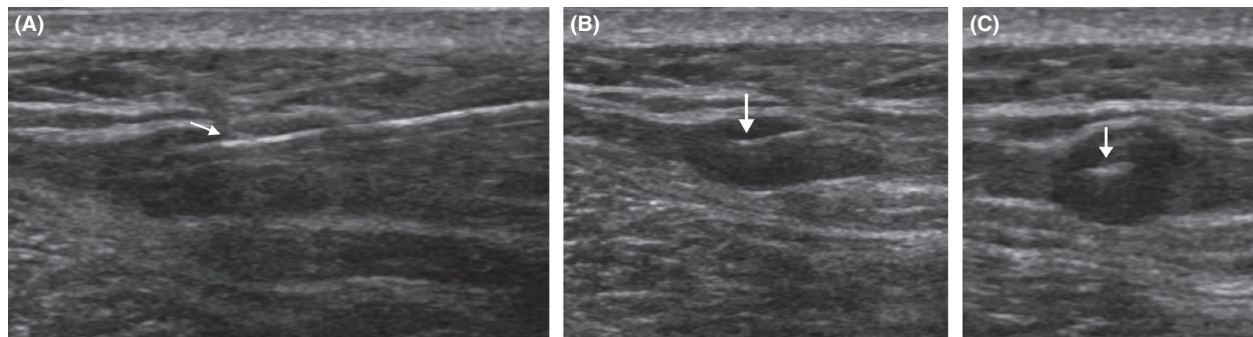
Ultrasound guided seed insertion (A) Long-axis view showing seed deployment needle (arrow) within a hypoechoic posterior chest wall mass corresponding to the lesion seen on the PET-CT study. (B) Long-axis and (C) short-axis views of the lesion taken immediately after seed deployment. The seed is seen as a linear echogenic structure (arrow).
